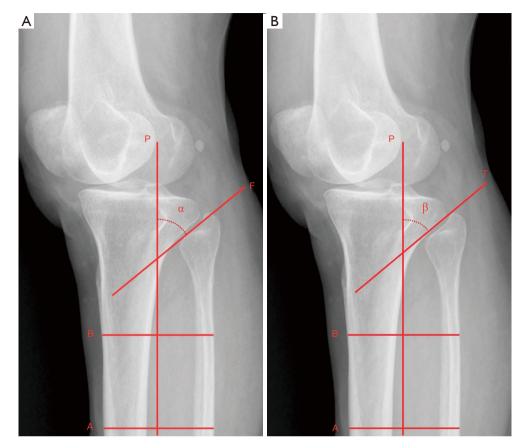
Measurements of the fibular inclination angle and tibial inclination angle of the PTFJ surface on radiographs. (A) The longitudinal axis (line P) of both fibula and tibia was determined by connecting the mid-points of two lines (line A and line B) drawn along the medial-to-lateral width of the diaphysis of the fibula and tibia. Line F was drawn along the fibular surface of the PTFJ. The fibular inclination angle was defined as 90° minus the acute angle (α) subtended by line P and line F. (B) A similar approach was used to determine the tibial inclination angle. The tibial inclination angle was defined as 90° minus the acute angle (β) subtended by line P and line T. PTFJ, proximal tibiofibular joint.
